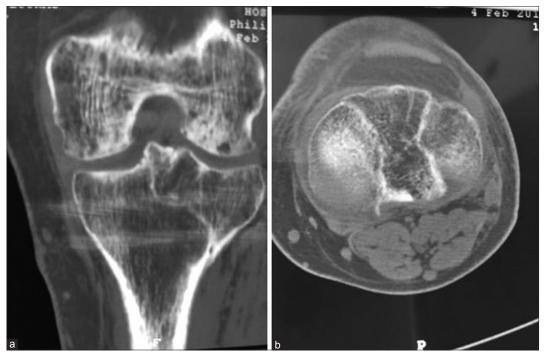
Postoperative CT scan in coronal (a) and axial plane (b) showing united proximal tibial fracture
